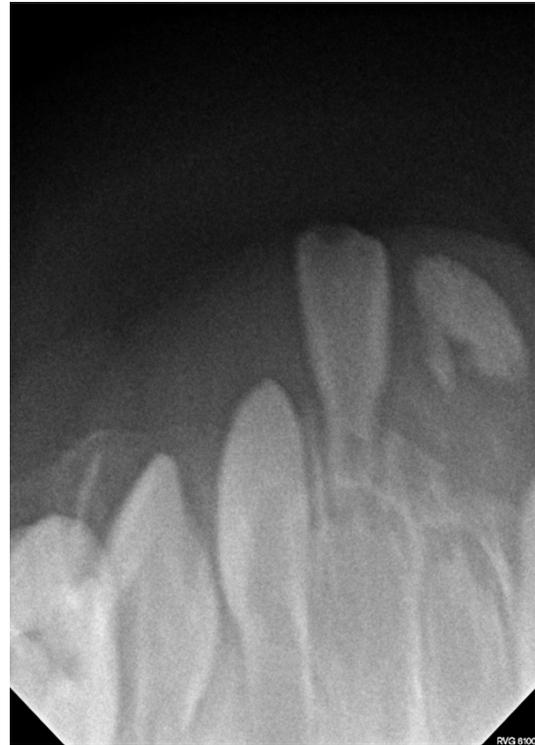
A periapical radiograph of a peripheral ossifying fibroma that developed after the extraction of a natal left mandibular central incisor in a 1-day-old boy. Focal calcification can be seen in the soft tissue mass.
